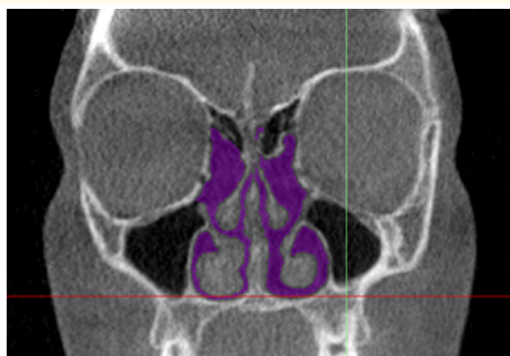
Post-op segmented CT-scan.
